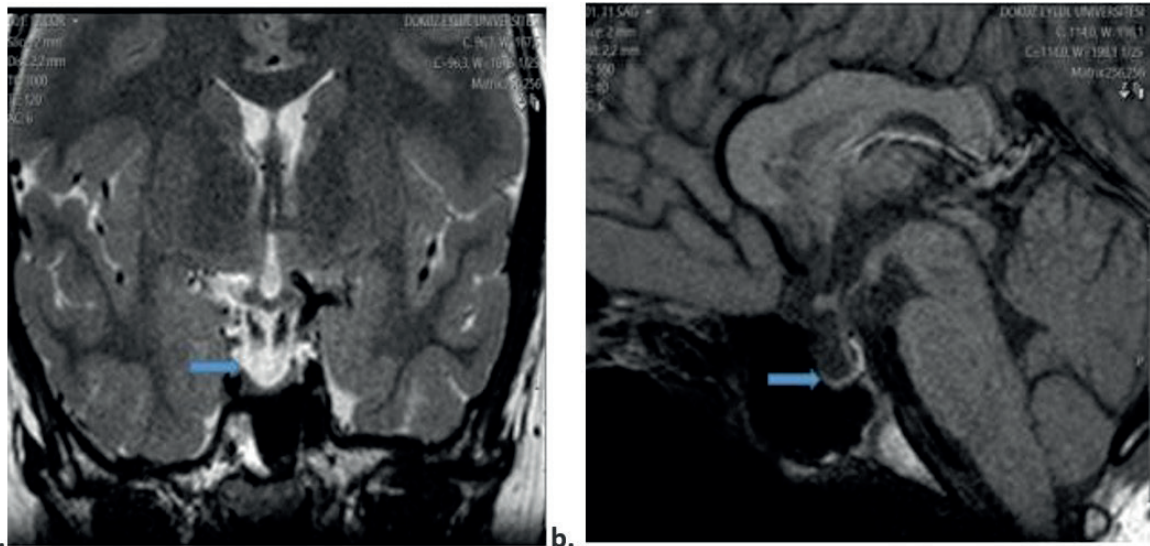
MRI brain scans of patient number 2 confirming the diagnosis of empty sella. a. T2weighted (arrow: fluid attenuated) coronal section shows the increased signal intensity of the CSF occupying the sella turcica b. T1-weighted mid-sagittal section that demonstrates a fluid filled sella turcica with a flattened pituitary gland (arrow) at the base of the pituitary fossa.
